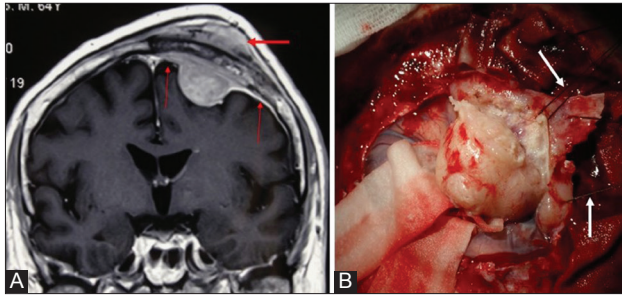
Magnetic resonance imaging of a typical convexity meningioma with large areas of dural involvement. The invasion of meningioma into the bone and subcutaneous tissue is evident (thick arrow), as is meningeomatous dural tail (thin arrows) that needs to be removed together with the tumor, posing additional problem for the dural reconstruction (A). Intraoperative image of meningioma removal. Holding sutures are placed to aid with careful elevation of the tumor (arrows). The dura was excised and later reconstructed with soft tissue grafts (B).
